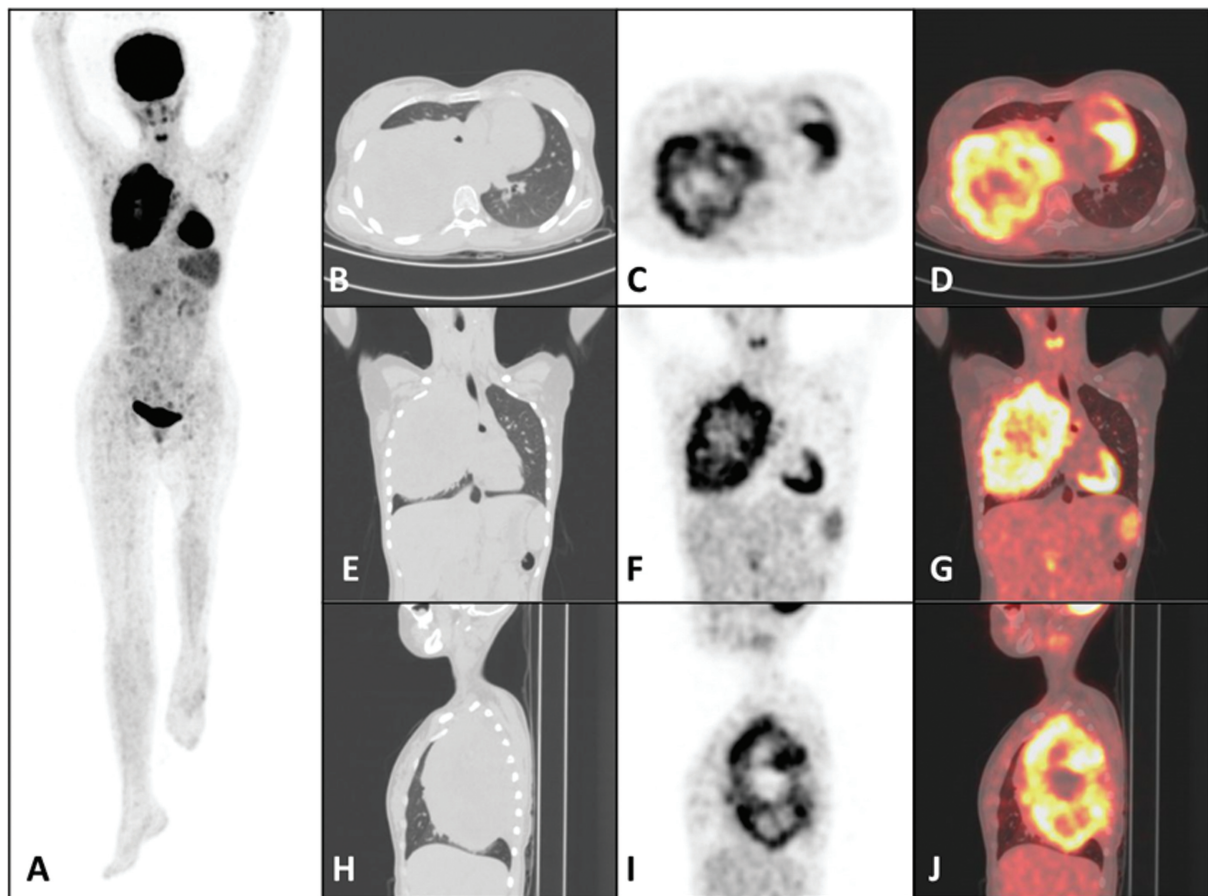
(A) Anterior maximum intensity projection of whole-body ^{18}F -fluorodeoxyglucose positron emission tomography (^{18}F -FDG PET). Noncontrast computed tomography (CT; lung window), PET, and fused PET/CT: (B–D) axial, (E–G) coronal, and (H–J) sagittal images showing metabolically active heterogenous soft-tissue lesion with central necrotic area involving almost a significant area of the right lung parenchyma, measuring $10.7 \times 11.2 \times 16$ cm (maximum standardized uptake value [SUV_{max}] of 8.05).
